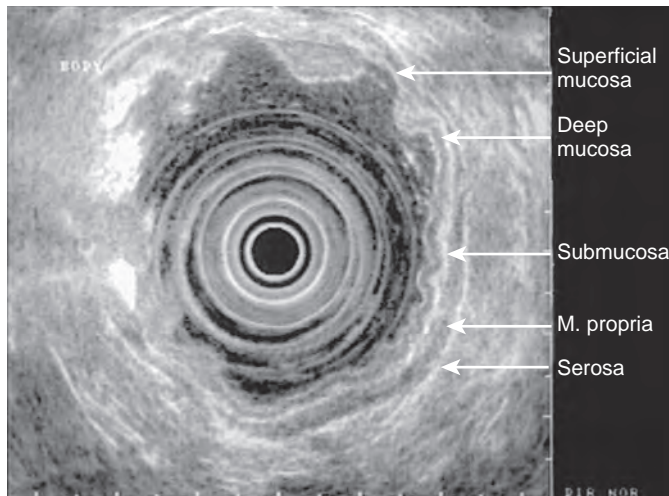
Endoscopic ultrasound appearance of the normal gastric wall. Note the typical five-layer wall pattern with a total wall thickness of only several millimeters. (Arrows denote the corresponding wall layers.)
